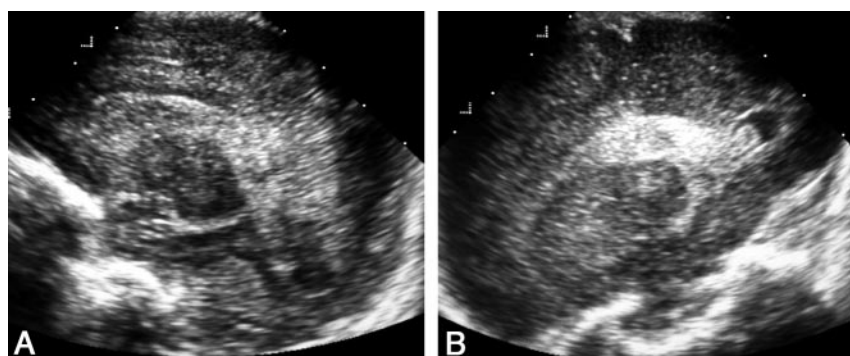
Sonograms of a hemorrhage originating in the left choroid plexus.
